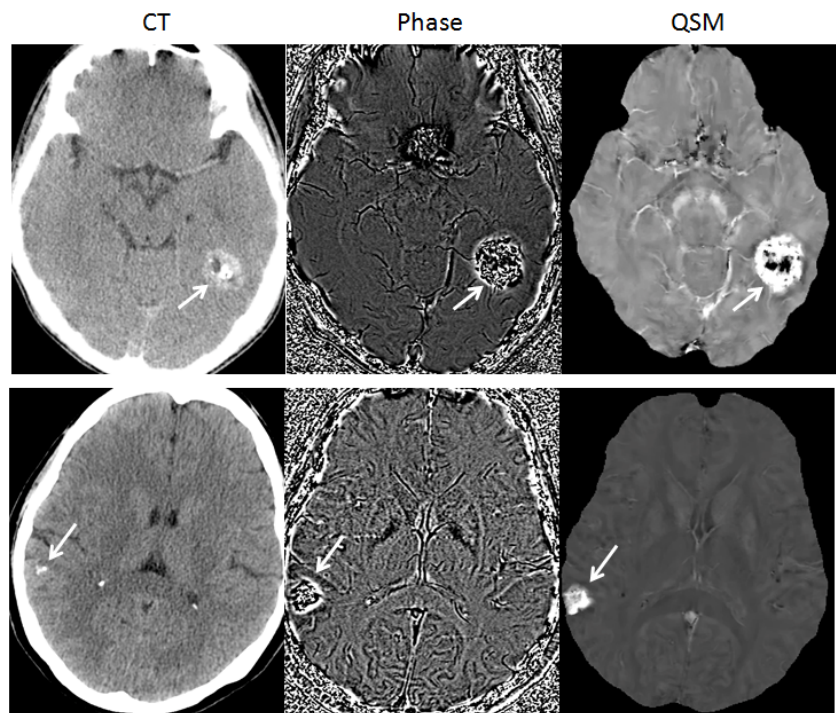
Representative cases of CT, phase and QSM. In the first patient (top row), CT showed a calcified lesion with a dim bright rim, the same lesion on the phase image had a noisy appearance, while on QSM it showed as hyperintense lesion with a hypointense core. In the second patient, CT showed a small calcified lesion, the same lesion on the phase image again had a noisy appearance, while QSM showed a non-uniform hyperintense lesion with the periphery brighter than the center.
